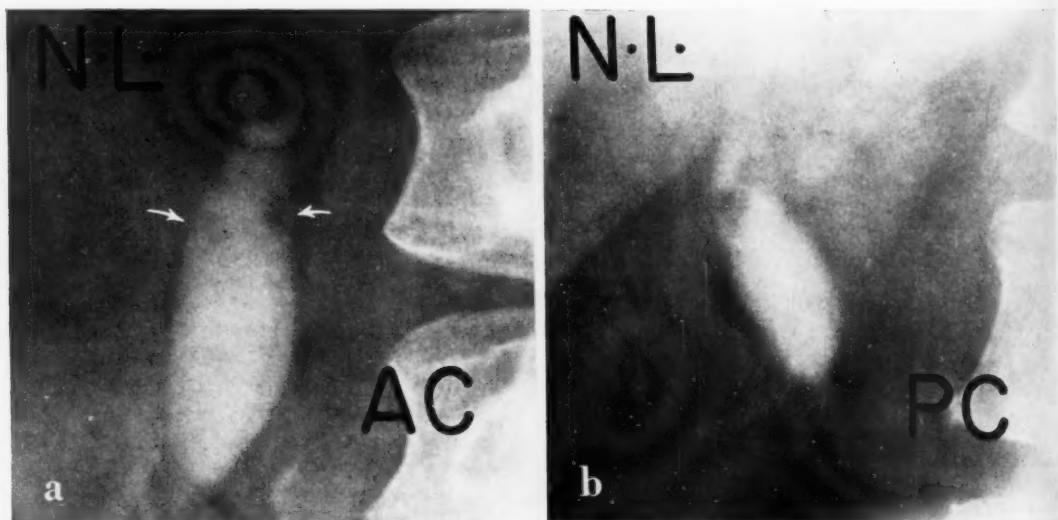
Roentgenograms in the erect position, (a) before and (b) after a fat meal. *Note* —
